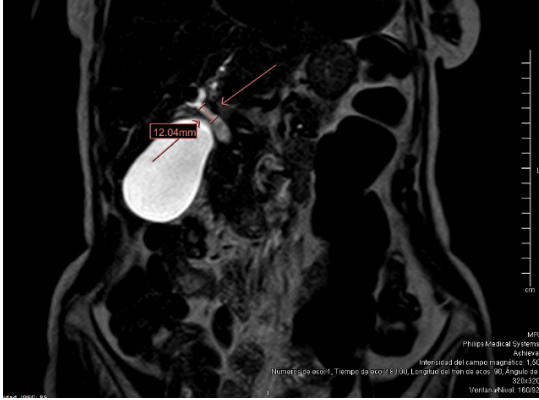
Magnetic resonance imaging showing a short-segment stricture of the proximal CHD.
